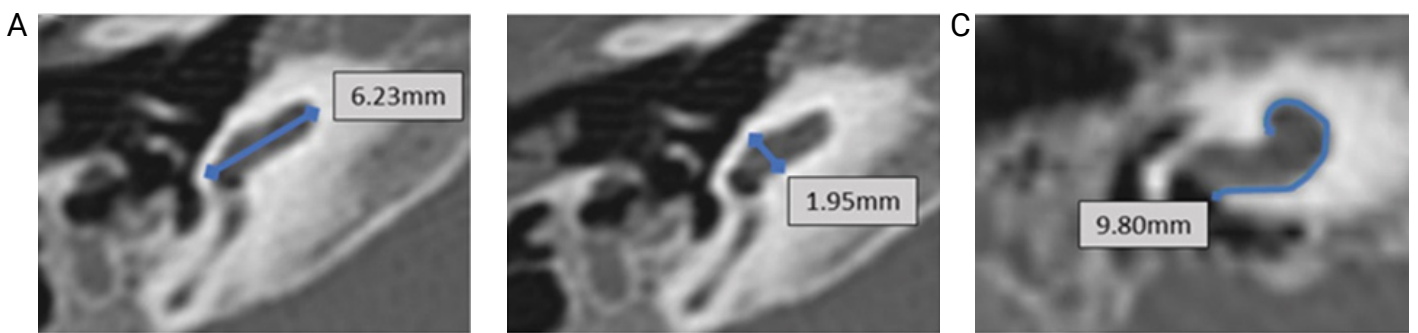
Computed tomography axial reformatted images showing measurements (mm) of the right cochlea as described by Pamuk et al. [3]. (A) presents the measurement of the basal turn length (6.23 mm), (B) the basal turn maximum height (1.95 mm), and (C) the mean cochlear duct lateral wall length (9.80 mm).
